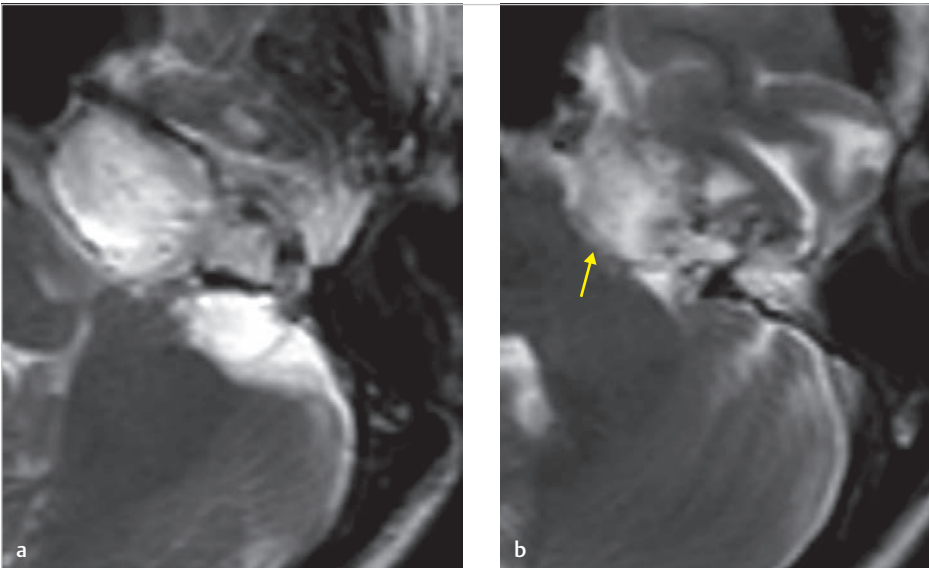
The axial image of T2-weighted MRI (a) shows a massive high-signal lesion corresponding to cholesteatoma. The MRI, more cranial slice (b), shows that the cholesteatoma protrudes to the CP angle, starting to push the brain stem (*arrow*).
